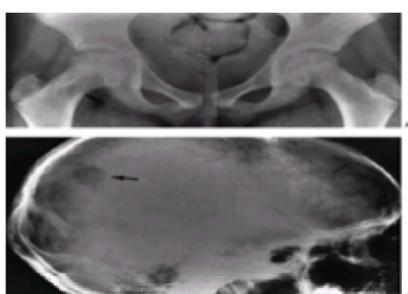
Eosinophilic granuloma, with multiple bone involvement, in a 9-year-old girl who had progressive symptoms of pain and limp involving the right hip. A: Anteroposterior radiograph of the pelvis demonstrates a lytic lesion in the right femoral neck. Biopsy defined the diagnosis. Follow-up radiographs, taken 5 months
